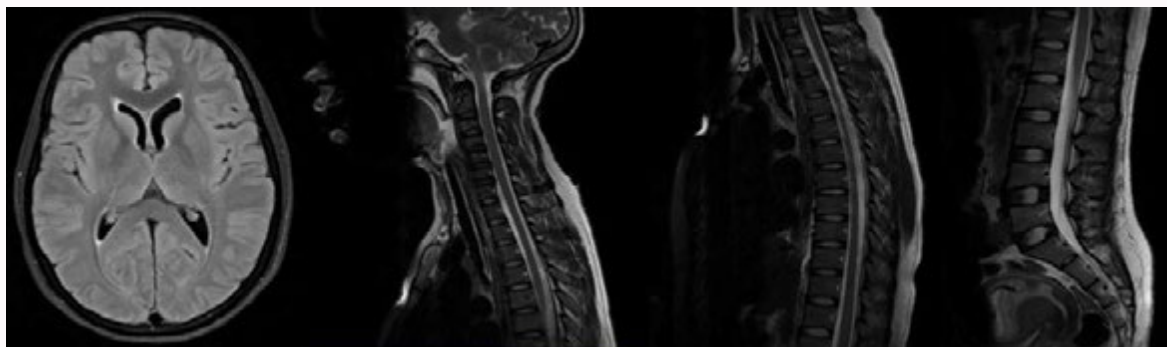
MRI brain and spine showed no abnormalities.
